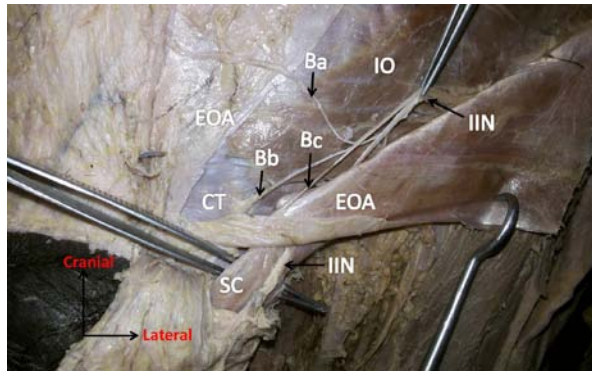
Dissection of left groin region showing the unusual path of branches of the ilioinguinal nerve (IIN). (Ba, Bb and Bc: branches of the IIN; SC: spermatic cord; CT: conjoint tendon; EOA: external oblique aponeurosis; IO: internal oblique muscle)
